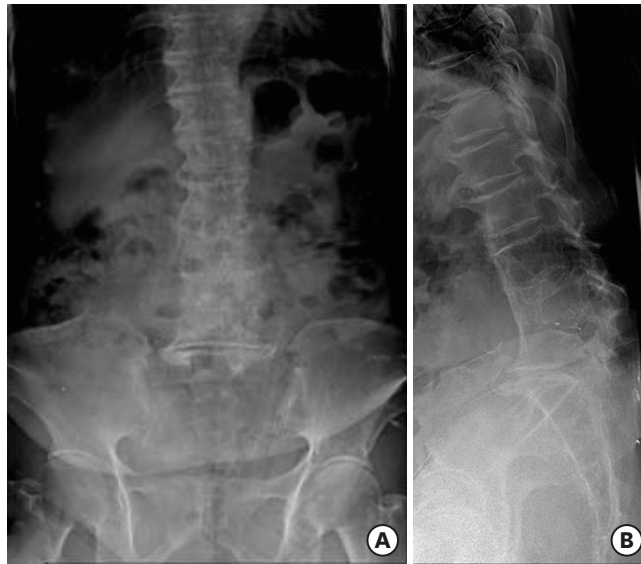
Preoperative anterior posterior (A) and lateral (B) radiographs show the complete fusion of three vertebral bodies.
